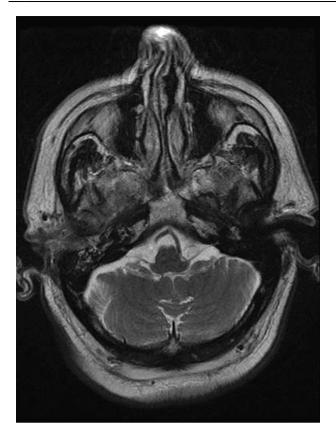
Magnetic resonance image showing skull base osteomyelitis.
